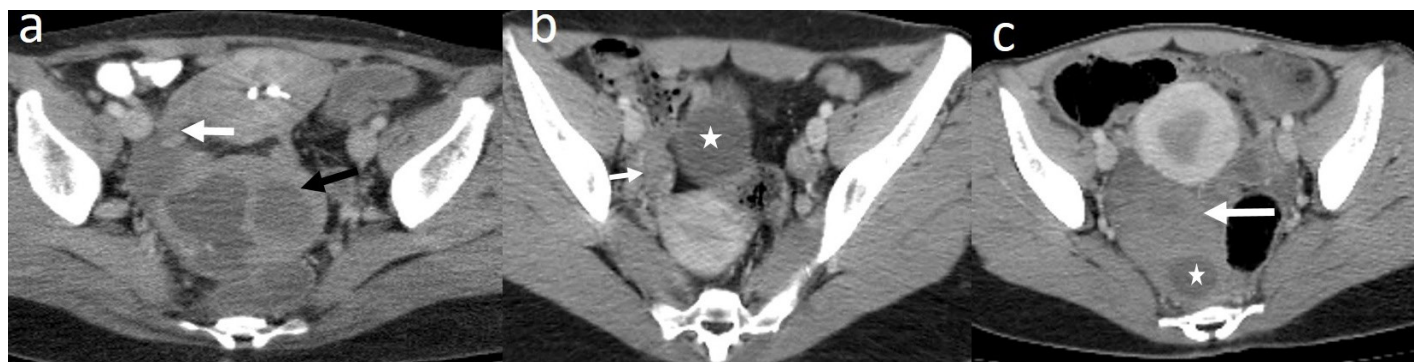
a) Axial pelvic CT image shows a multilocular cystic mass causing torsion (black arrow), with the right ovary displaced to the midline behind the uterus; Thickening of the ovarian pedicle and uterine deviation toward the torsion side are seen (white arrow); b) Axial image shows pedicle thickening (white arrow) and anterior midline displacement of the torsed right ovary (star); c) Axial image shows the enlarged torsed ovary (white arrow) in the midline, posterior to the uterus, with a cystic lesion (star)
